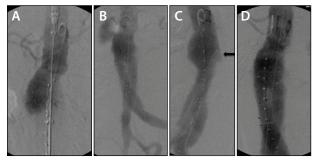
Intraoperative images showing CTA initially (A), post-EVAR (B), type Ia endoleak (C), and type Ia endoleak resolved after placement of EndoAnchors (D).
